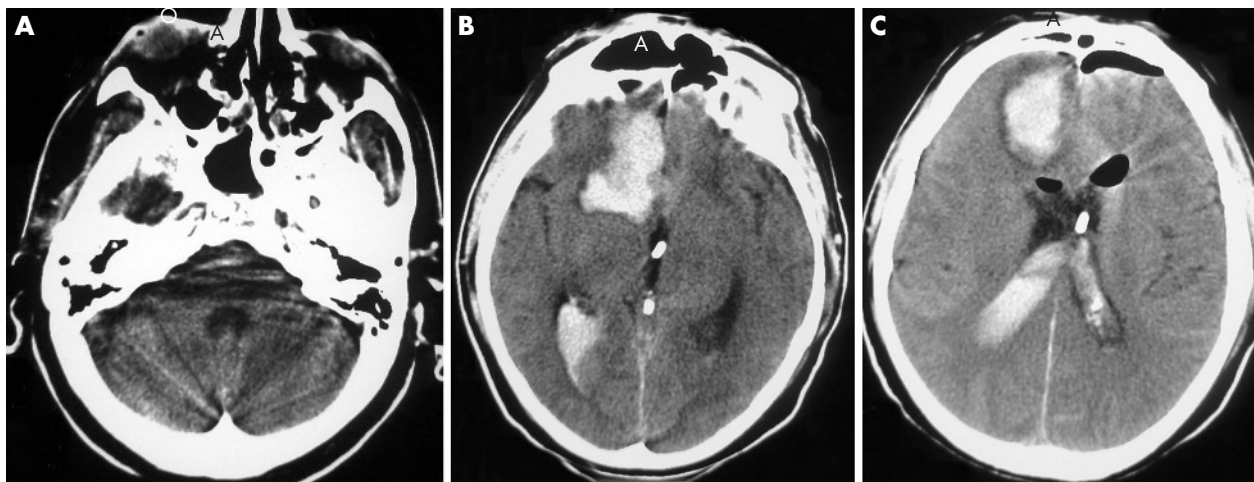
Immediate postoperative computed tomography scan (patient 7).
